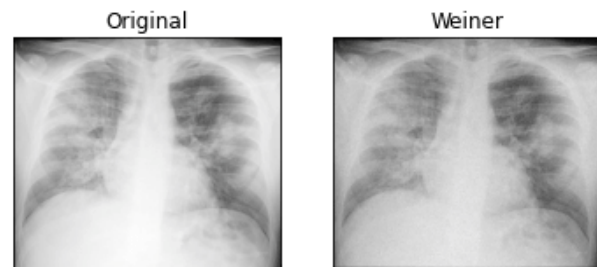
(d). Outputs of first X-Ray image before and after filtering it using Weiner Filter
